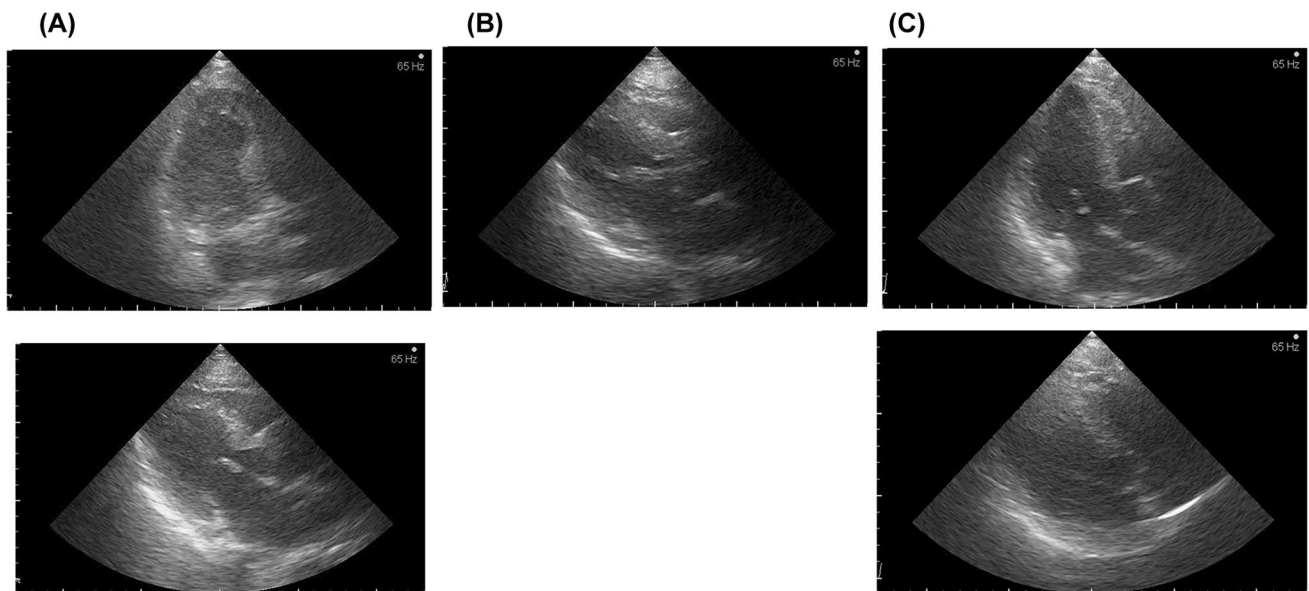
Apical three-chamber view on transthoracic echocardiography. a Was on the 6th day, b was on the 8th day during IMPELLA support, and c was on the 29th day
